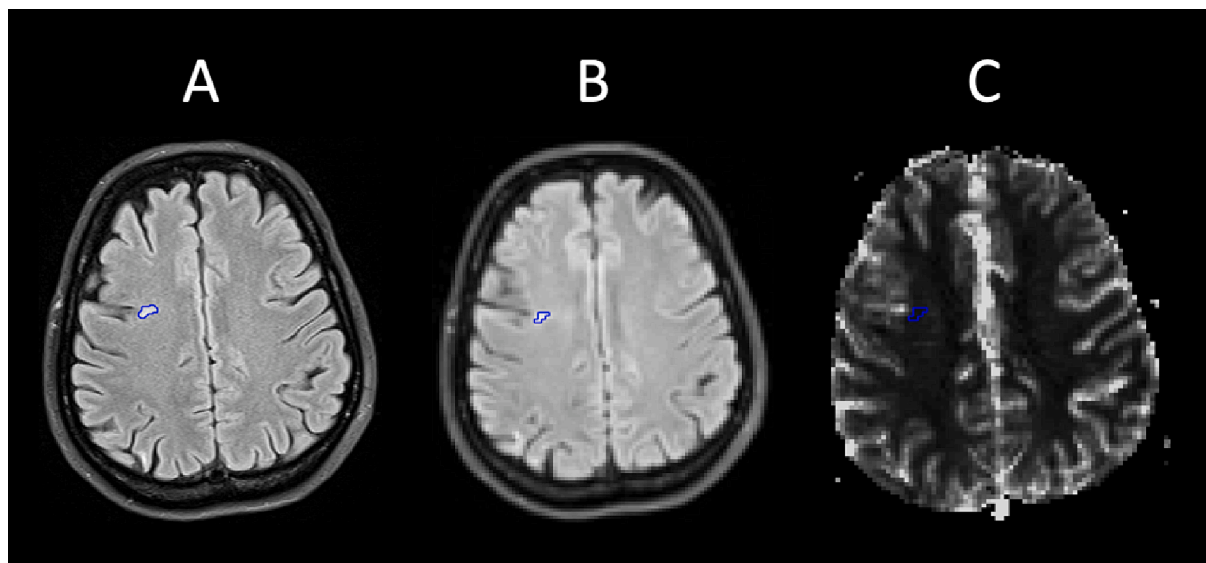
One of the WMH ROIs identified by the FLAIR image (A). Co-registering the FLAIR and PWI scans (B) ensured correct ROI placement in the PWI maps (C; example for CBF). WMH = White matter hyperintensity, ROI = region of interest, FLAIR = fluid-attenuated inversion recovery, PWI = perfusion weighted imaging, CBF = cerebral blood flow.
